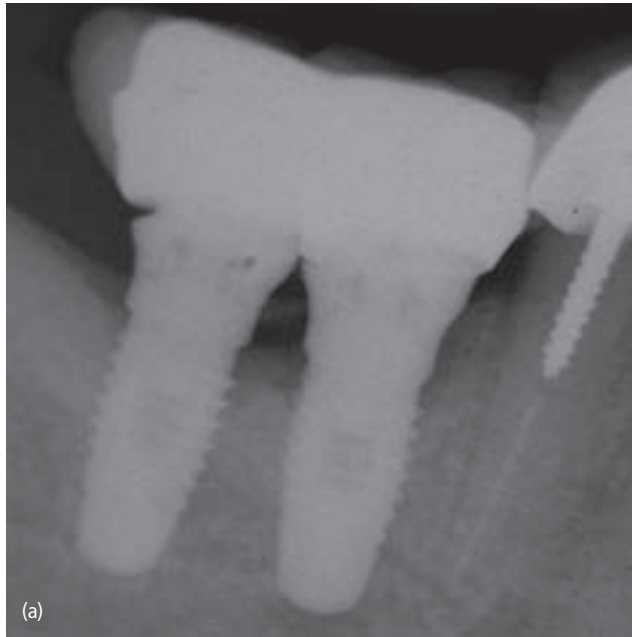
(a) Radiograph of flared abutments which should not be used when implants are too close to each other. The embrasure is non-existent and cement remains subgingivally. (b) Radiograph demonstrating that the abutments have been repaired or replaced and new restorations have been fabricated which demonstrate adequate marginal adaptation and a sufficient gingival embrasure.
